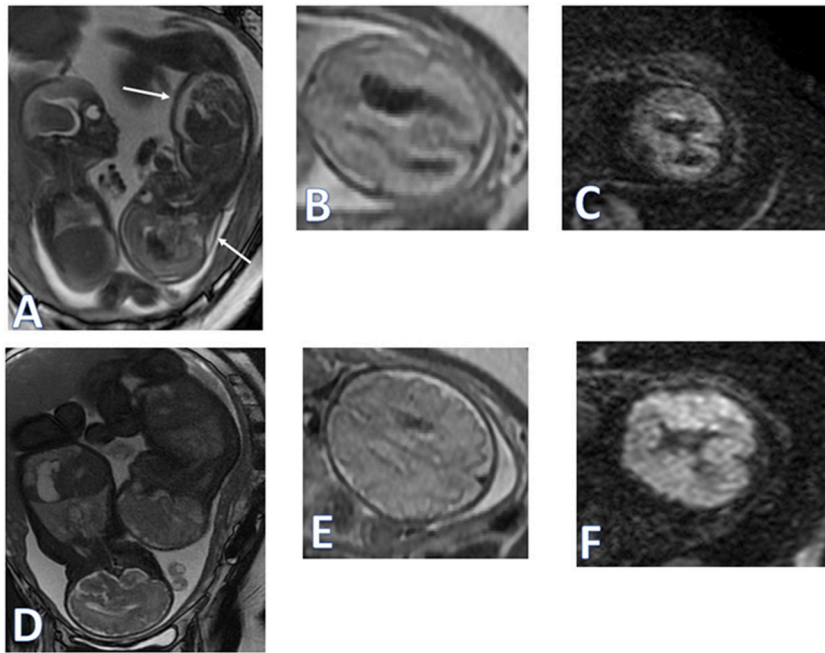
A 25-GW monochorionic twin pregnancy. One fetus had haemorrhagic components in the lateral ventricle on FIESTA images (A). GM-IVH displayed an extremely low signal on both T2WI (B) and DWI (C). Note that the ascites and hydrops fetalis are shown (arrow). On seven-week follow-up MR (D–F), this fetus grew as well as the normal fetus according to the estimated growth trend (D), and both the ascites and hemorrhage components largely resolved (E–F). The patient had a caesarean delivery at 35 GW (birth weight: 2220 g/1890 g, 1-min Apgar score: 9/9).
